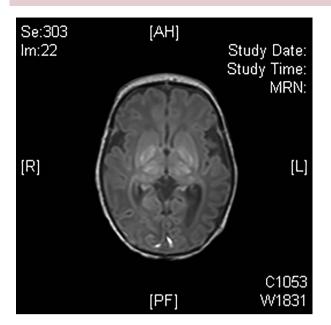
MR scan of brain (T1-weighted) showing bilateral basal ganglia enhancement associated with hypoxic–ischaemic injury to the term brain.
